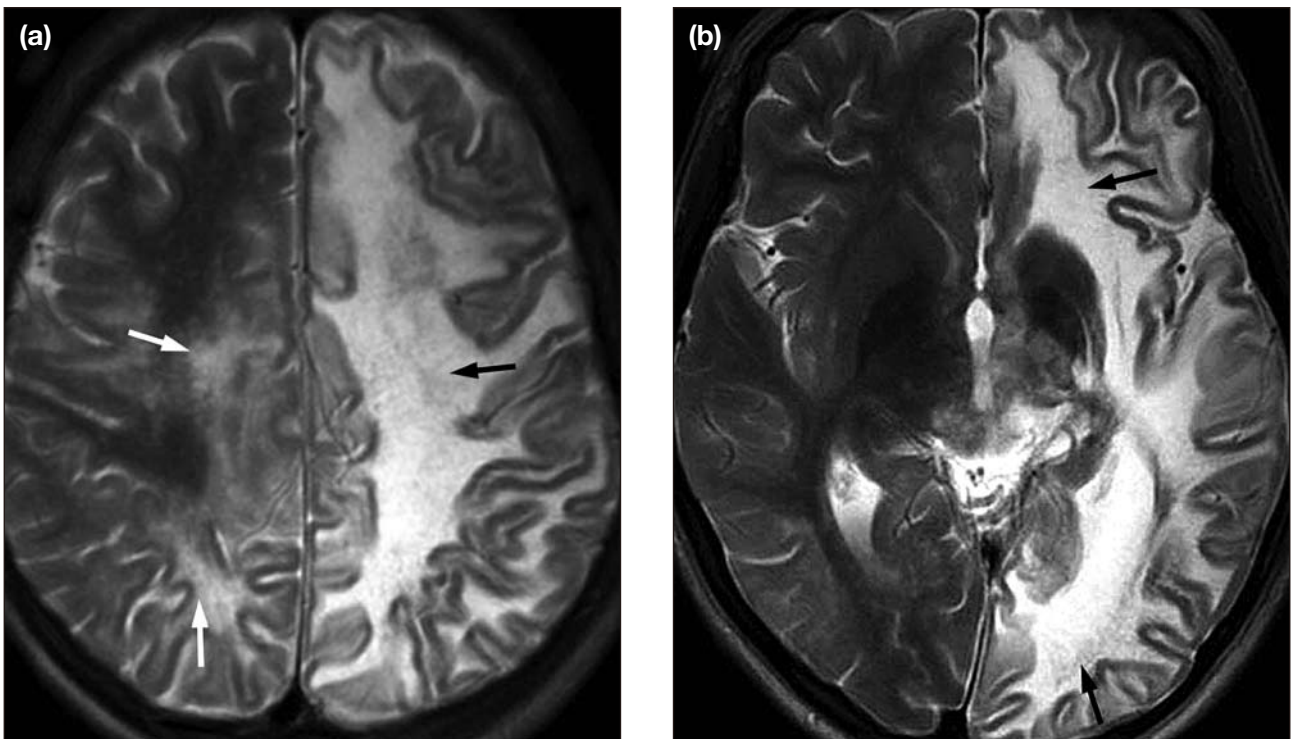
Follow-up T2-weighted axial magnetic resonance images at 4 months showing progression of demyelination within the entire left hemisphere (black arrows). (a) There are a few new areas of demyelination in the right centrum semiovale and parietooccipital regions (white arrow); and (b) the left cerebral sulcal spaces are widened suggestive of generalized left cerebral atrophy.
